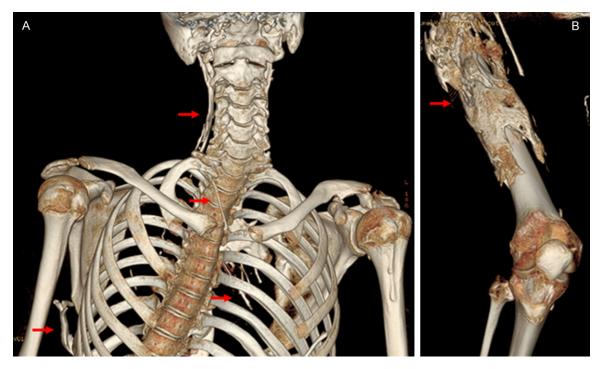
CT scan with 3D reconstruction from patient 5. A. CT scan with 3D reconstruction showing bone ribbons at the cervical region and thorax. B. CT scan with 3D reconstruction showing HO at the proximal region of the femur.
